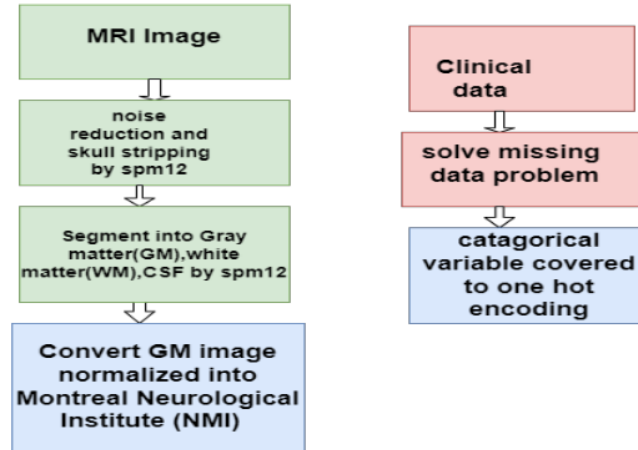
Details of data preprocessing on MRI and Clinical data
